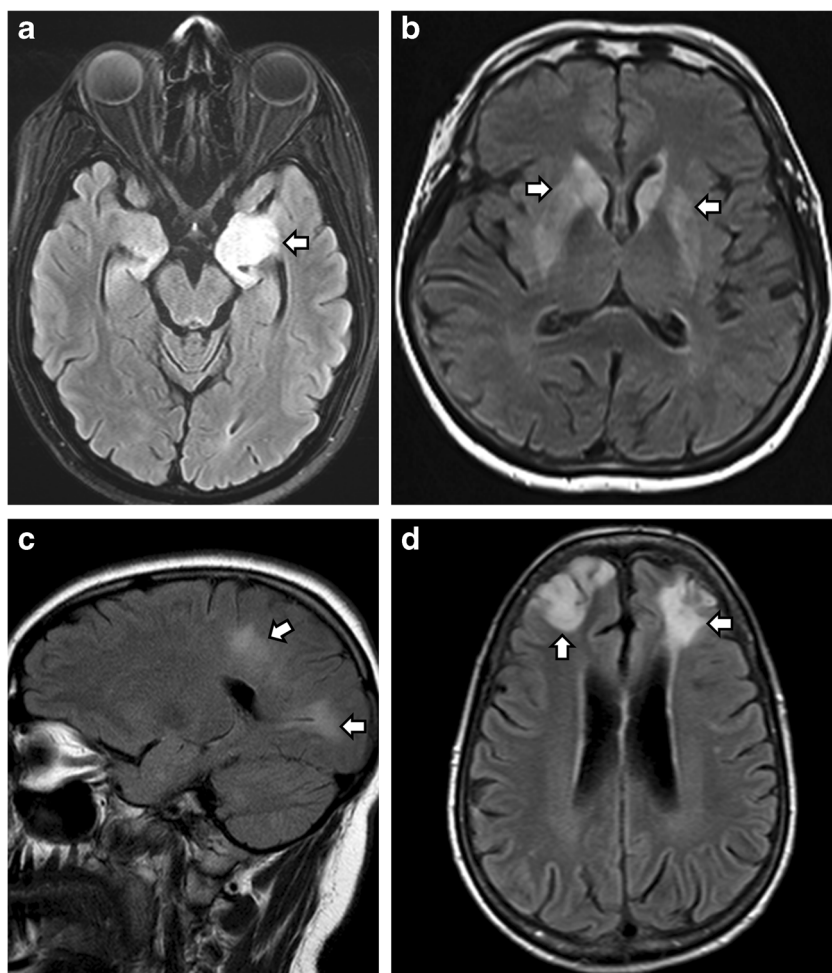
Representative examples of brain MRI abnormalities seen with autoimmune dementia. Axial (a, b, and d) and sagittal (c) fluid-attenuated inversion recovery (FLAIR) images: a Anti-Ma2 limbic encephalitis with mesial temporal signal abnormality (arrow) associated with seminoma; b anti-CRMP5 chorea with caudate and putamen hyperintensity (arrows) associated with small cell lung cancer; c anti-MOG antibody associated ADEM in an adult with multifocal white matter abnormality (arrows) (no cancer detected); d anti-GABA-A antibody autoimmune encephalitis with multifocal cortical and subcortical T2-signal abnormalities (no cancer detected).
